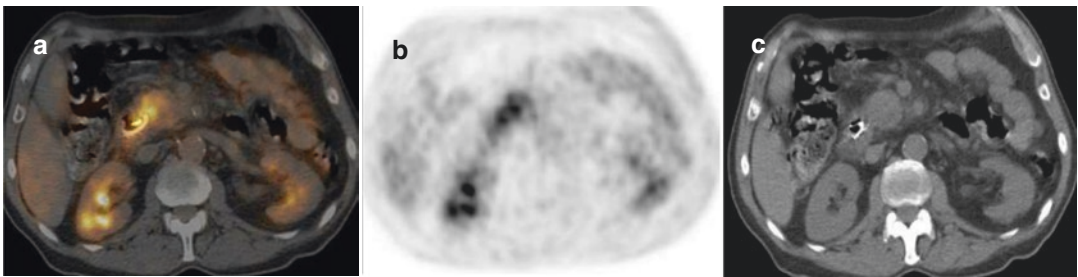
FDG-PET/CT imaging of a 69-year-old male with a pancreatic head mass and significant elevation of serum CA19–9 level to 1775 U/mL. Axial fused FDG-PET/CT imaging (a) demonstrating heterogeneous FDG uptake throughout the pancreatic head mass with a maximal SUV = 5.0. Axial FDG-PET (b) and noncontrast CT (c) are shown for comparison. Endoscopic
